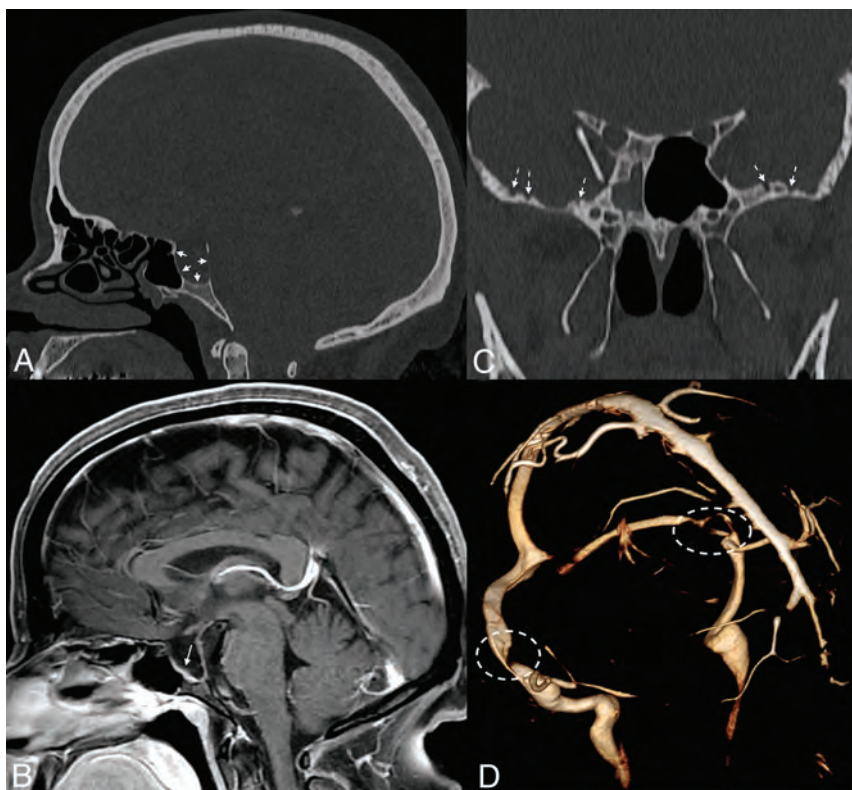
Sella expansion and skull base pitting in IIH. Sagittal CT image (A) in a 38-year-old woman with pseudotumor cerebri demonstrates marked expansion of the osseous walls of the sella (*short solid arrows*), with frank dehiscence posteriorly. Corresponding sagittal MR image (B) shows flattening of the pituitary tissue along the floor of the sella (*long solid arrow*). Prominent pitting is also noted along the anterior margins of both middle cranial fossae (*dashed arrows*, C). 3D reconstruction image of an MRV (D) demonstrates smooth tapering of the bilateral transverse sinuses (*dashed ovals*), compatible with IIH.
